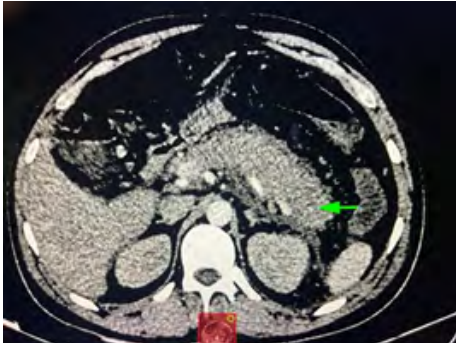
CT scan image depicting Necrotizing pancreatitis of the body and tail.
